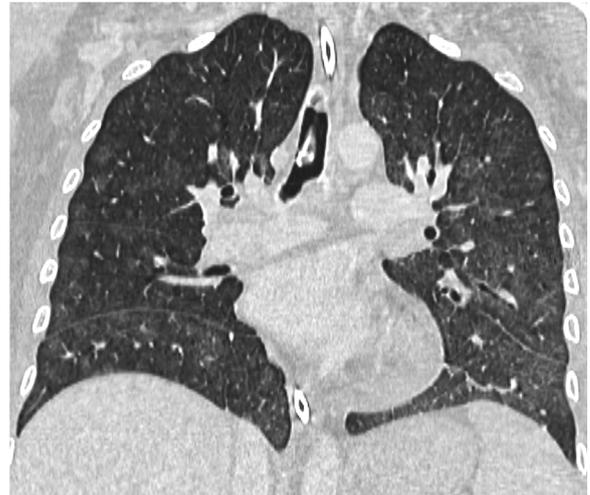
Diffuse alveolar haemorrhage (DAH) in a 44-yr-old woman who developed thrombotic thrombocytopenic purpura while undergoing chemotherapy for stage IV breast cancer. HRCT image reformatted on the coronal plane reveals bilateral, lobular ground-glass opacities, with mosaic pattern.
